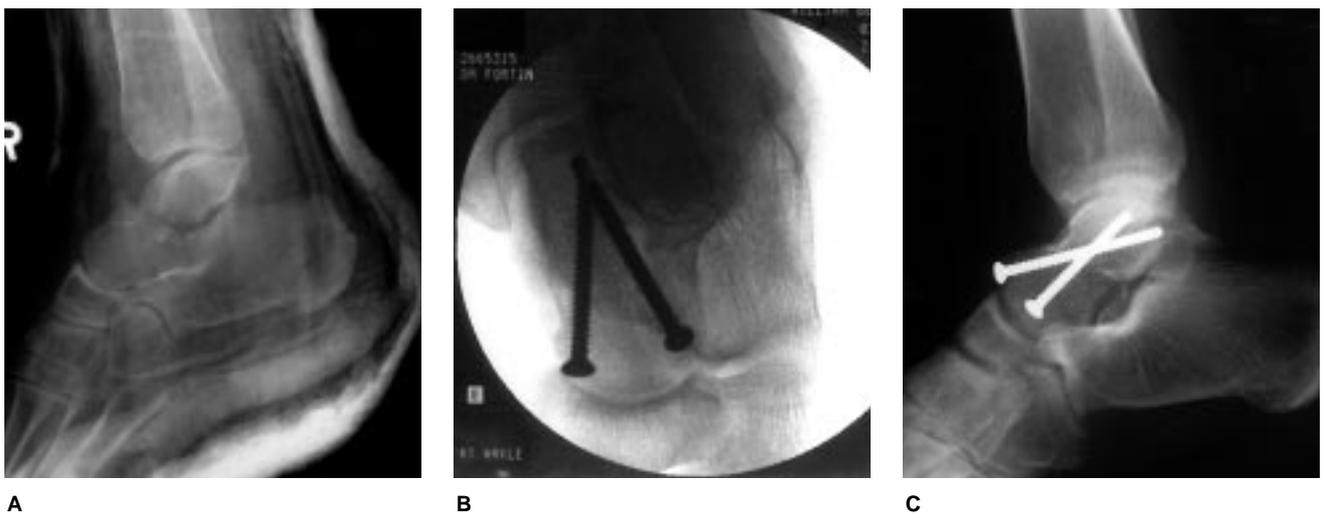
A, Preoperative lateral radiograph shows a displaced fracture of the talar neck. B, Canale view demonstrates anteromedial and anterolateral lag-screw placement. C, Postoperative lateral radiograph shows reduction of the talar neck and subtalar joint.
